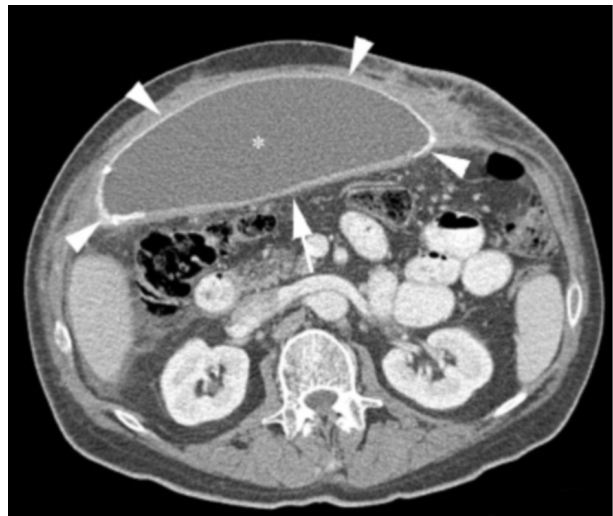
Axial enhanced CT through the mid abdomen demonstrating a low density seroma (\*) deep to mesh (arrowheads). Note that the posterior wall of the seroma consists of enhancing granulation tissue (arrow) that is lower density than the mesh overall but has a subjectively similar density in some regions, particularly near the midline.
